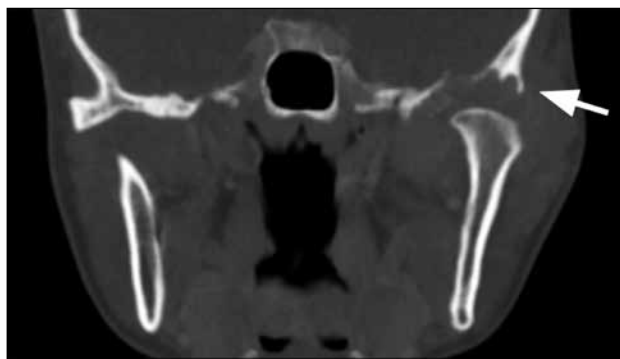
Coronal computed tomography image in bone window shows that the tumour erodes through the temporal bone (arrow).
